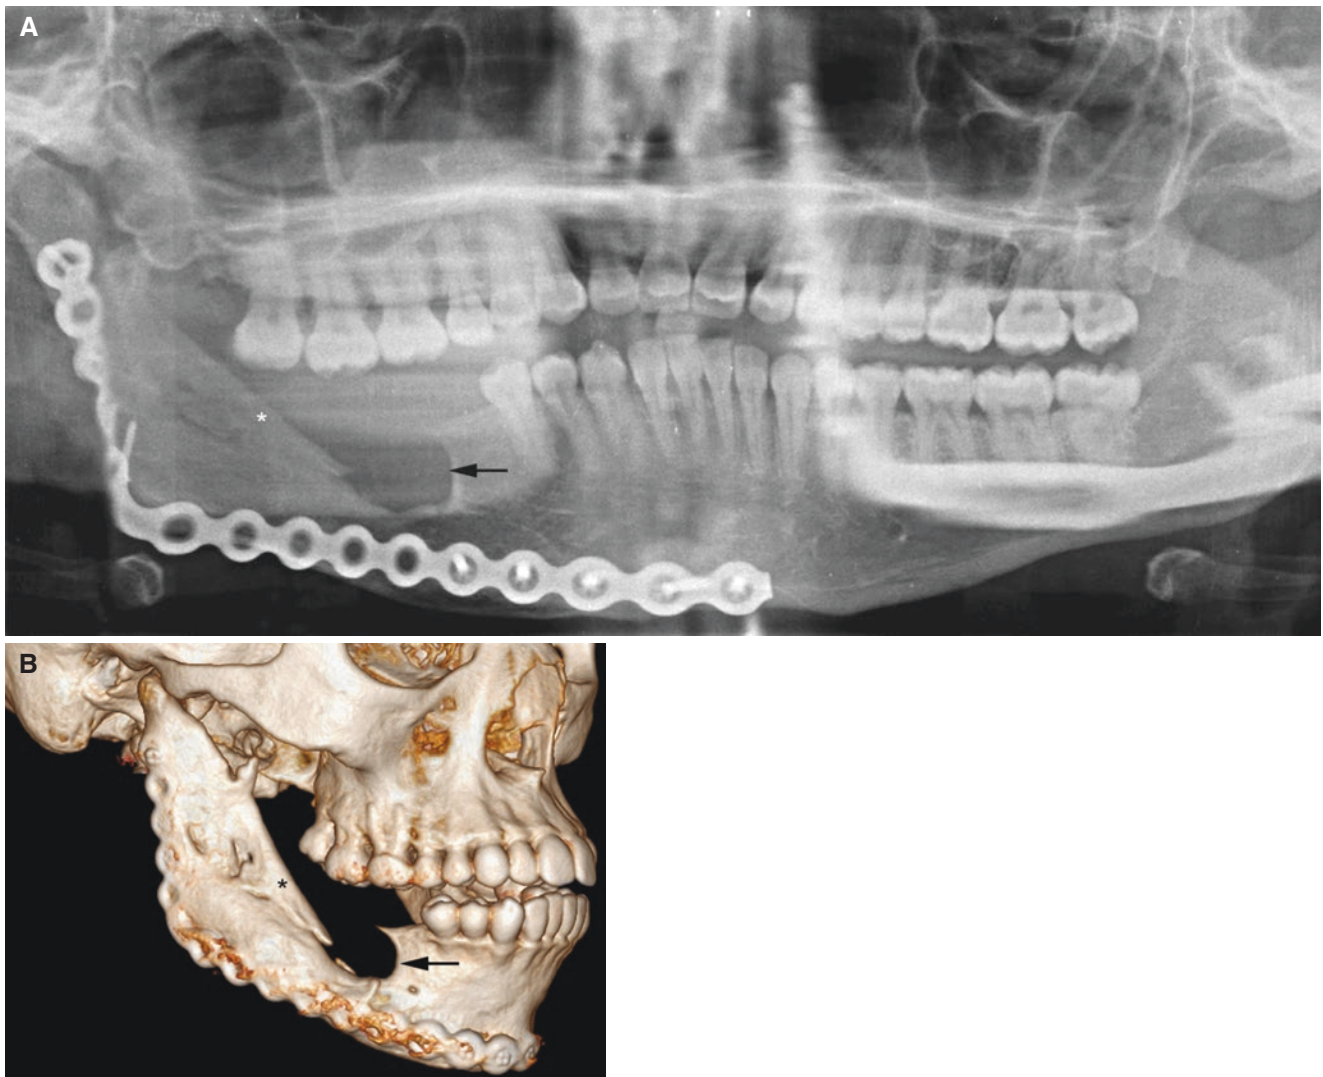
Ameloblastoma, recurrence involving graft, mandible; 24-year-old female. (A) Panoramic view and (B) 3D CT image show fixation plates and fibula graft (*asterisk*) with tumor recurrence between graft and remaining mandible (*arrow*)
